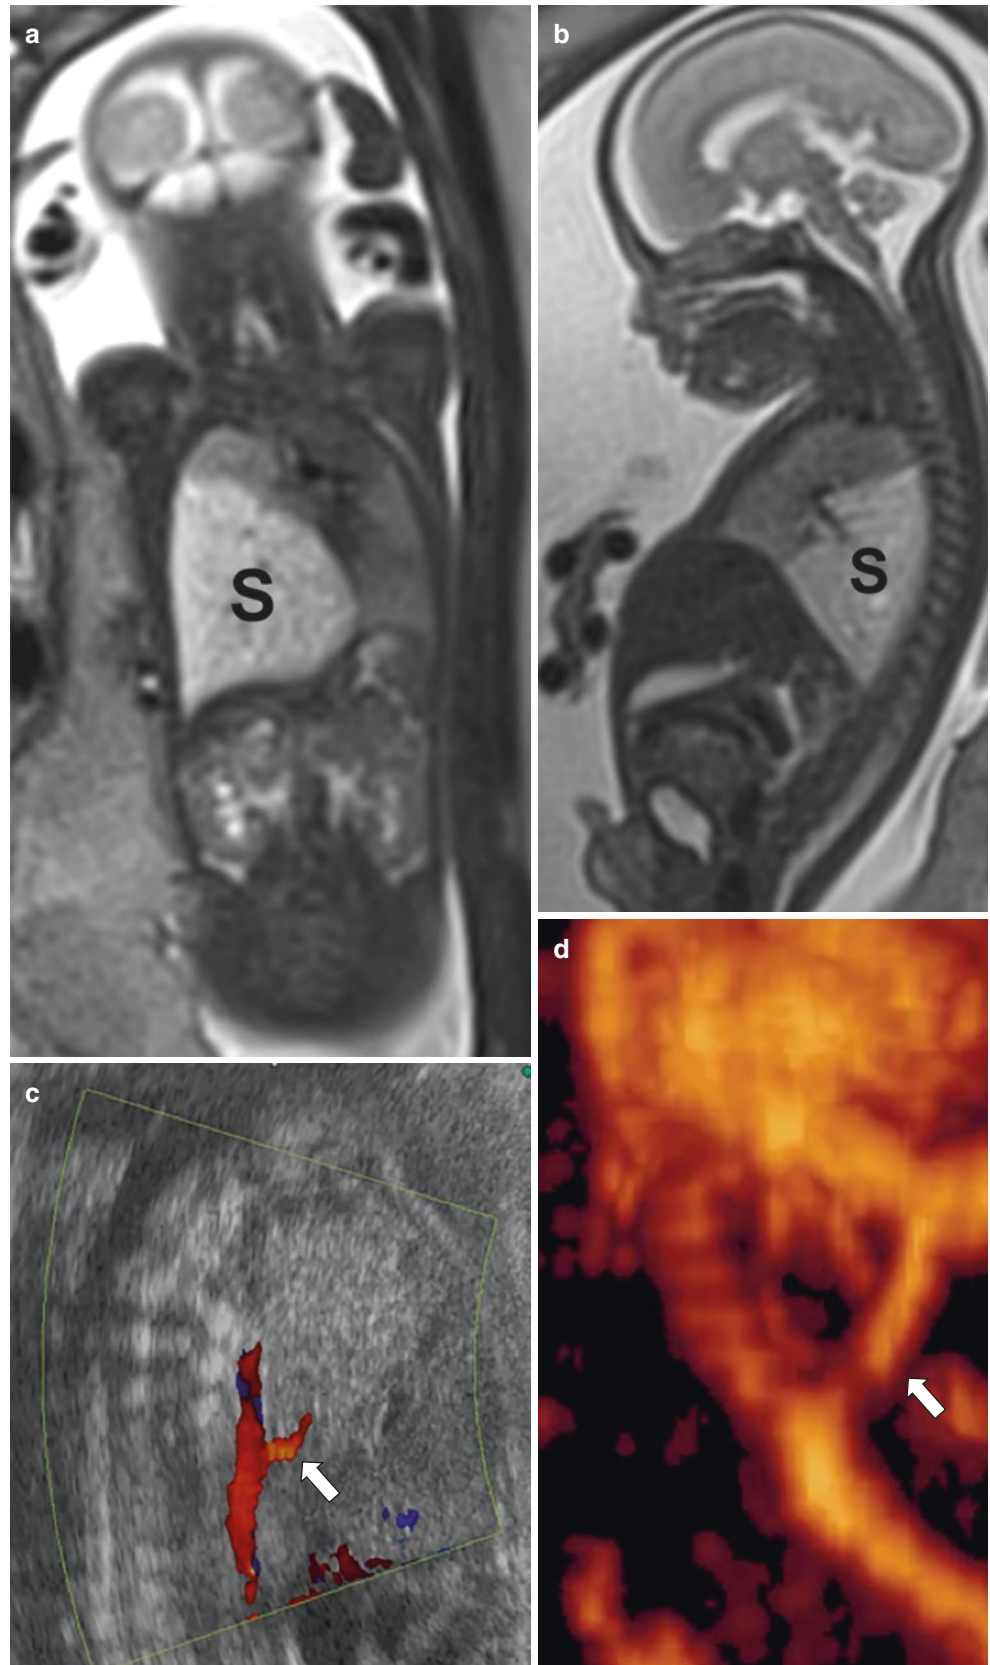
Extralobar infradiaphragmatic pulmonary sequestration on prenatal MR imaging. Coronal non-enhanced T2-weighted MR image shows hyperintense lesion (*arrow*) inferior to the left diaphragm
